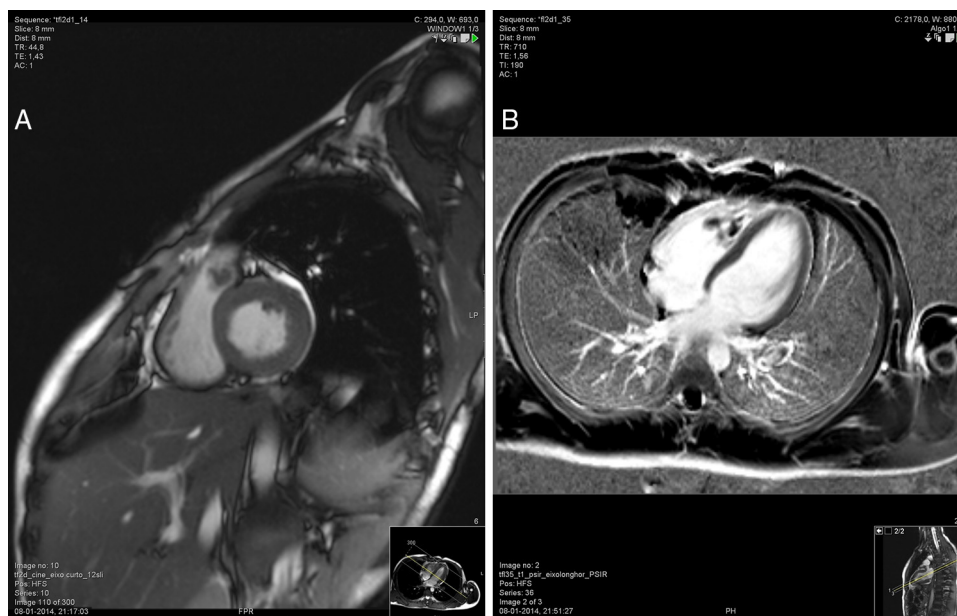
Contrast-enhanced cardiac MRI with thrombi visible in the right ventricle outflow tract (A), and in the right ventricle (B).
